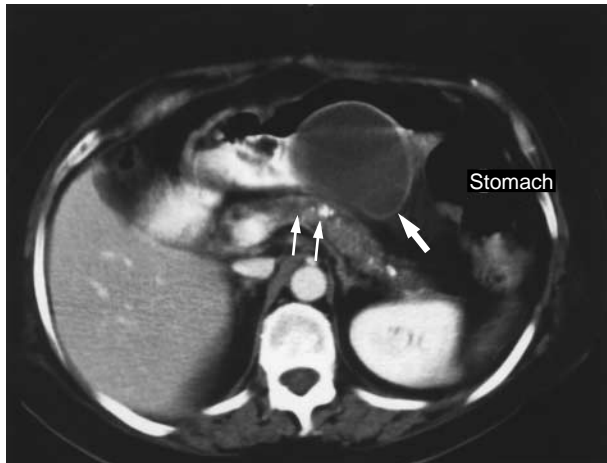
Dynamic Computed Tomographic Image Showing a Thin-Walled Pancreatic Pseudocyst (Thick Arrow) Compressing the Gastric Antrum and an Abnormal Pancreas with Ductal Dilatation and Calcifications (Thin Arrows).
